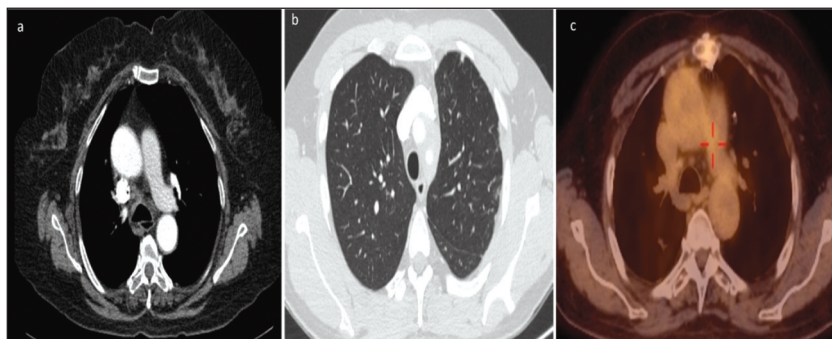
A) The lesion in the left anterior mediastinum is resolved after steroid treatment of 3 months. B) The reticular density and the peribronchial thickening seem to recover. C) There was no ^{18}F -fluorodeoxyglucose uptake on the positron emission tomography-computed tomography scan after steroid treatment.
